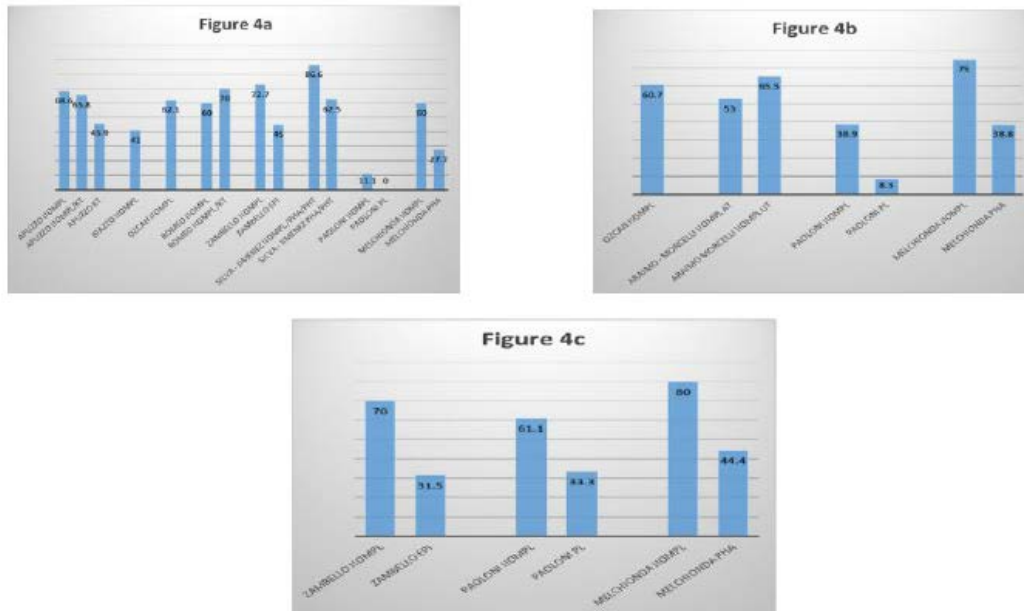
Percentage of decrease in pain according to the type of intervention. 3a only IOLPM groups; 3b IOLPM vs non-invasive treatments; 3c IOLPM vs invasive treatments. Abbreviations: ST: Short Term; MT: Medium Term; LT: Long Term; IOMPL: Intramuscular Infiltrations with Ozone in Lumbar Paravertebral Muscles; O3: Ozone; KT: Kinesiotherapy; PHA: Pharmacotherapy; EPI: Epidural Infiltration; PL: Placebo Infiltration; PHT: Physiotherapy; AT: Anatomical Technique; UT: Ultrasound Technique.
